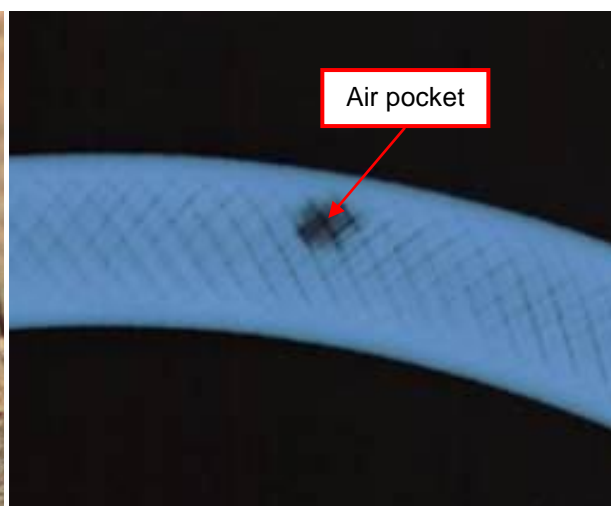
Radiograph of Hose 1
